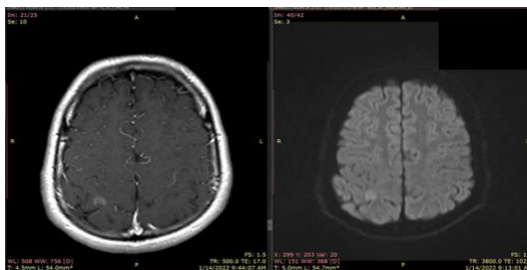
Second non-specific patient, recent MRI. Multiple, active, cerebral, demyelinating lesions in diffusion and contrast-enhanced Magnetic-Resonance Imaging. Source: Author's elaboration.
